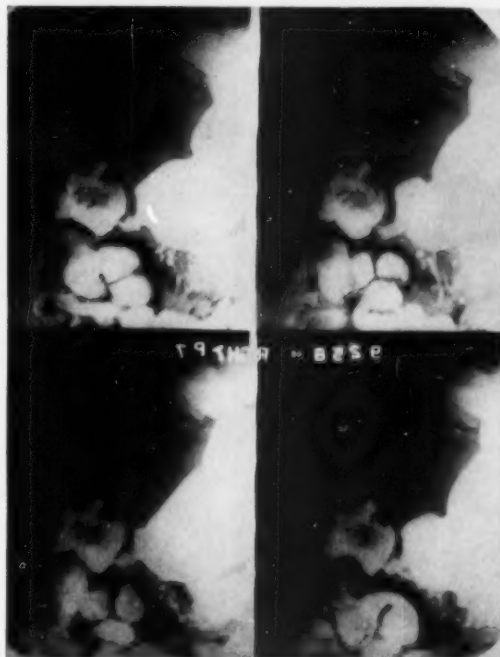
Case 4. G. B. X-ray interpreted as an infiltrative lesion in *pars pylorica* with partial hypertrophic type obstruction.
